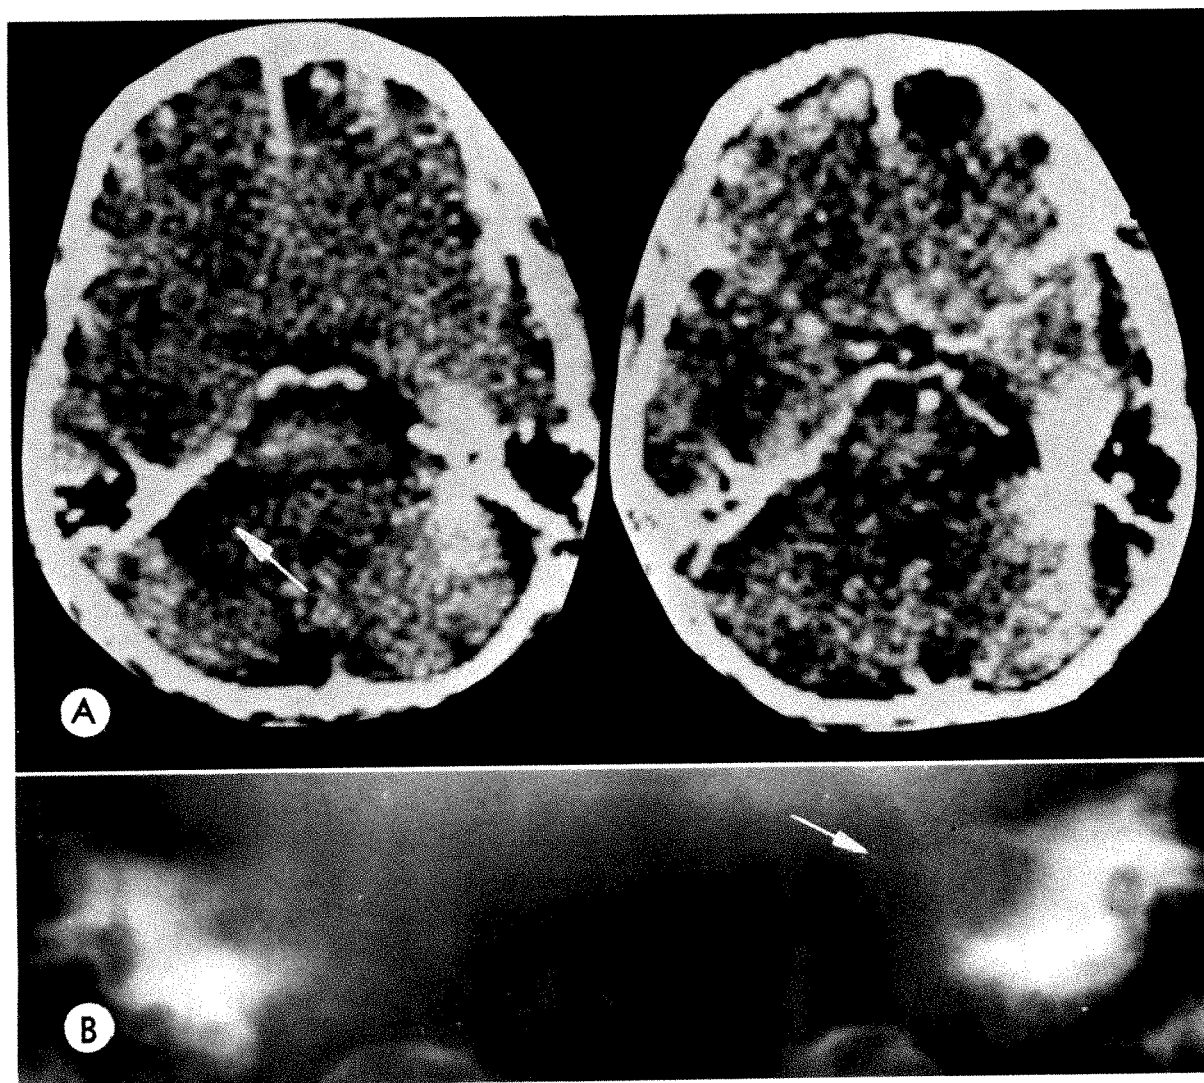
Left acoustic neuroma. A, CT scans without contrast (*left*) and following 300 ml meglumine diatrizoate (*right*). Normal left cerebellopontine angle (*arrow*); right cerebellopontine angle artifact. Undisplaced fourth ventricle. B, Coronal polytome laminogram showing widened abnormal left auditory meatus (*arrow*). Left-sided 1.5 cm neuroma confirmed at surgery.
